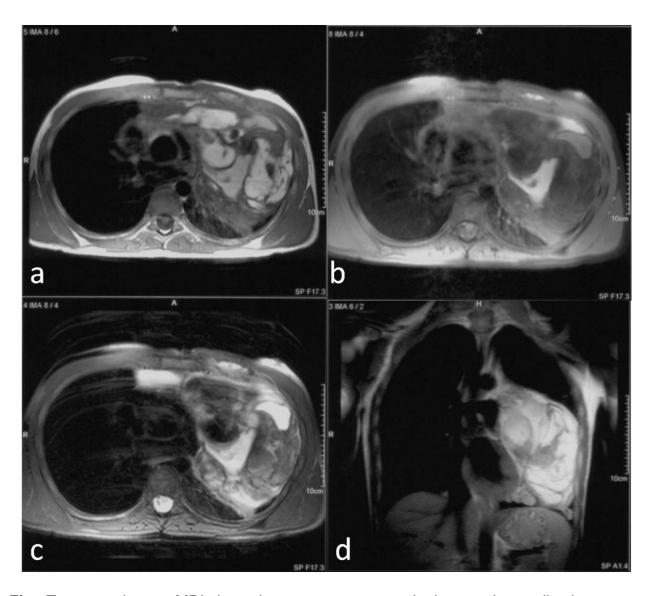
Teratocarcinoma. MRI shows heterogeneous mass in the anterior mediastinum, with soft-tissue and fat components.
